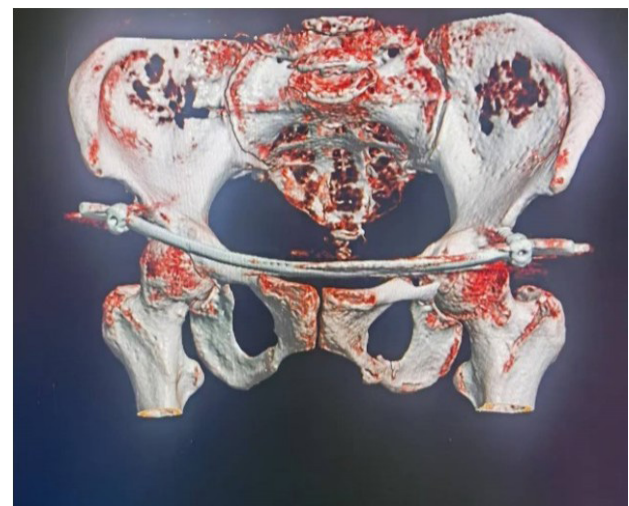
Postoperative CT three-dimensional reconstruction.
